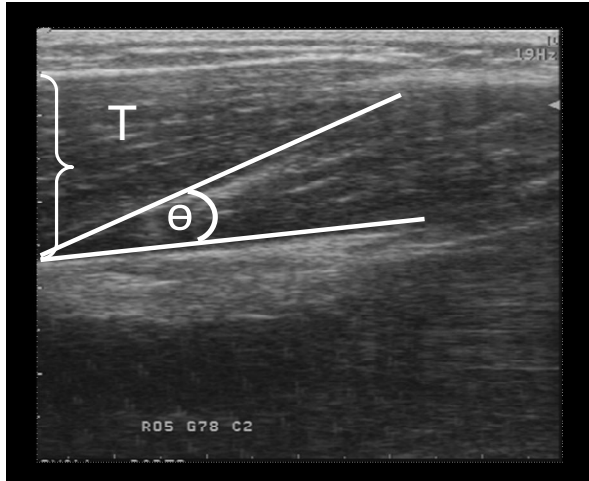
Ultrasound image showing for the long head of the Triceps Brachii muscle the thickness (T) and pennation angle (Θ).
